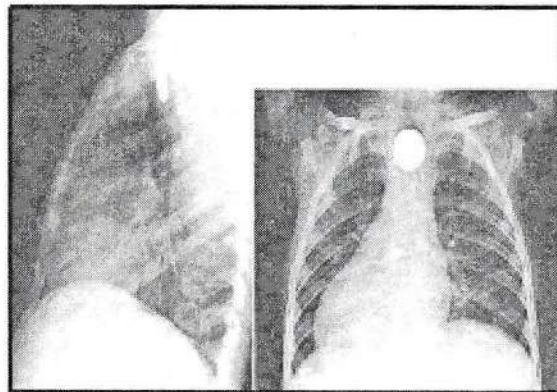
A radiopaque density noted on the esophagus in plain chest radiograph
